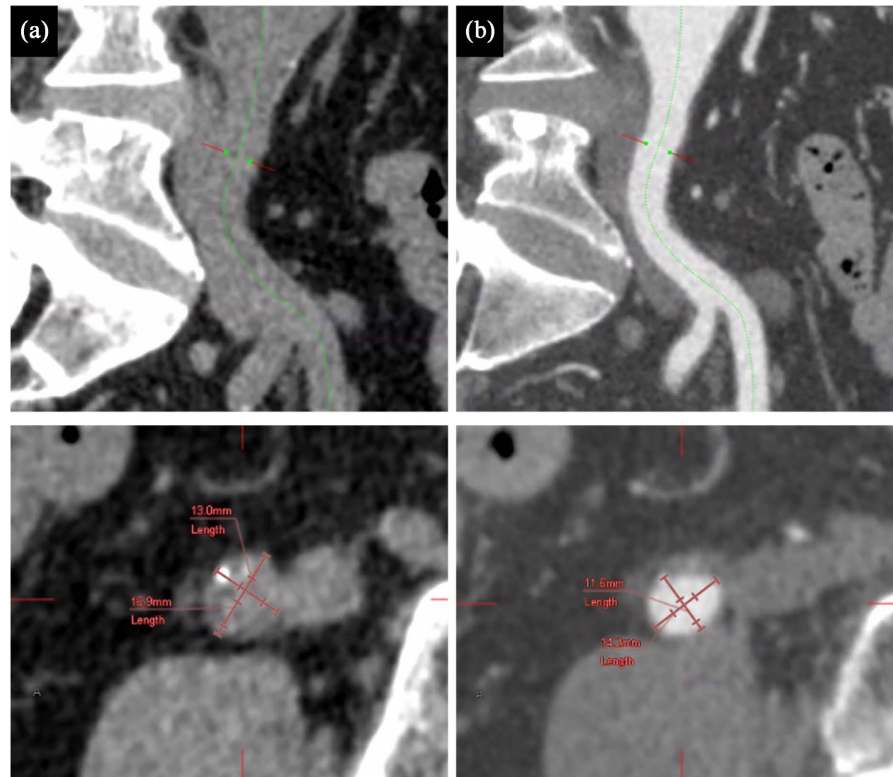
Cause of measurement errors. In non-contrast computed tomography (CT) scans (a), distinguishing the internal and external iliac arteries from the surrounding structures may pose challenges, particularly in cases with minimal visceral fat, compared with contrast-enhanced CT scans (b).
